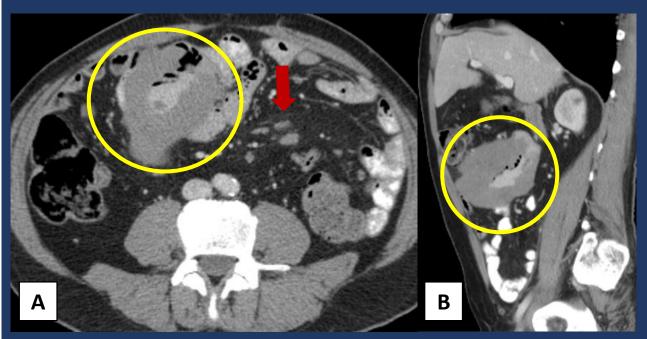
Axial (A) and sagittal (B) CT scans shows marked thickening of the ileum (circle) and adjacent mesenteric lymph nodes (arrow), typical findings of lymphoma.
